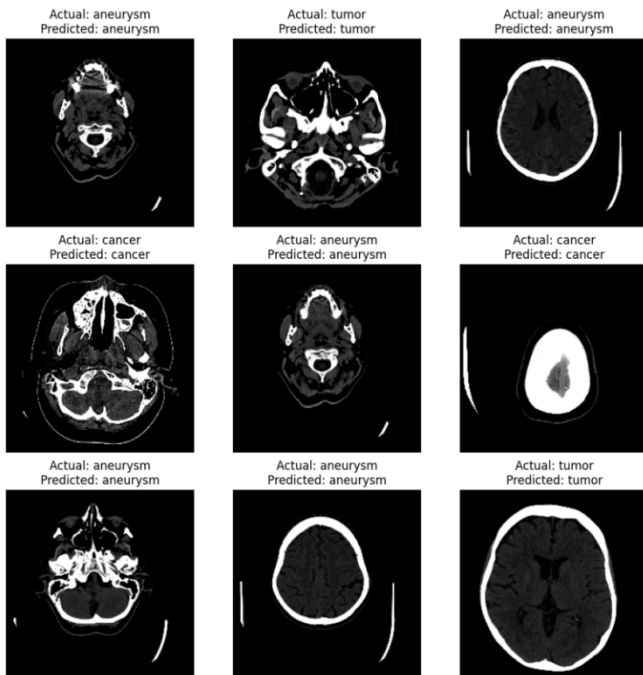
Brain CT classification images.
